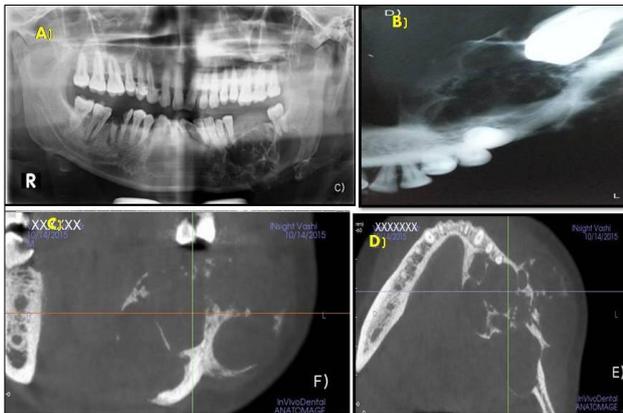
Photograph A) Orthopantomograph, B) Occlusal view, C) CBCT coronal view D) CBCT Axial view
